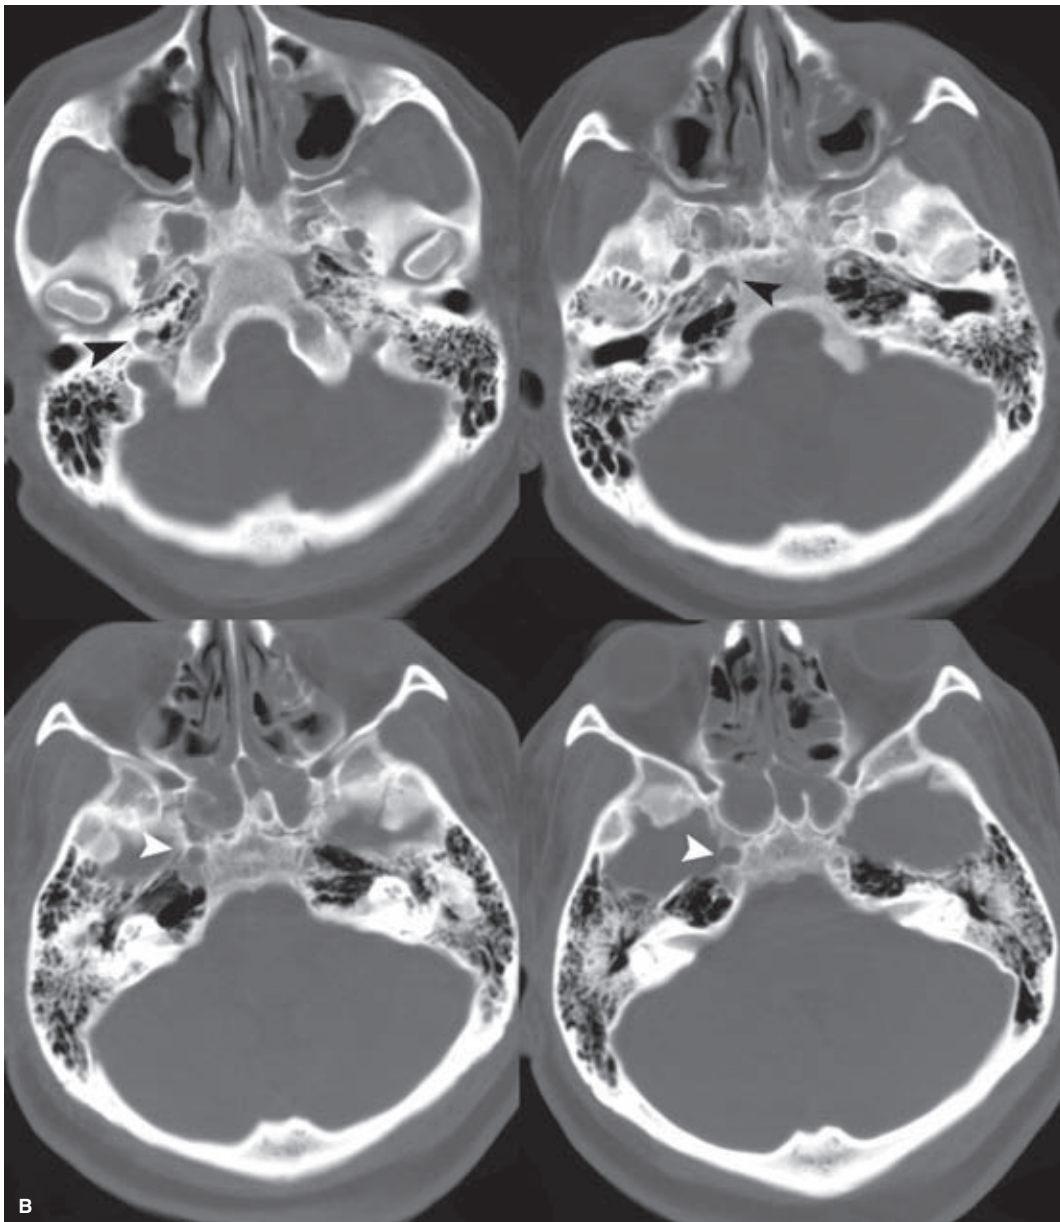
(A–B) Agenesis of the left internal carotid artery. In this patient, the left common carotid artery injection, lateral view (A), shows no evidence of an internal carotid artery. A long-standing occlusion or dissection could have allowed remodeling and healing of the artery to take place to a degree where no angiographic clue to the lost vessel might be apparent, although this would be unusual. In this patient, the CT scan of the skull base (B) shows a normal appearance of the bony landmarks for the carotid canal (*white and black arrowheads*) and foramen lacerum on the right, while those landmarks are absent on the left side, indicating that this is likely related to a prenatal event.
